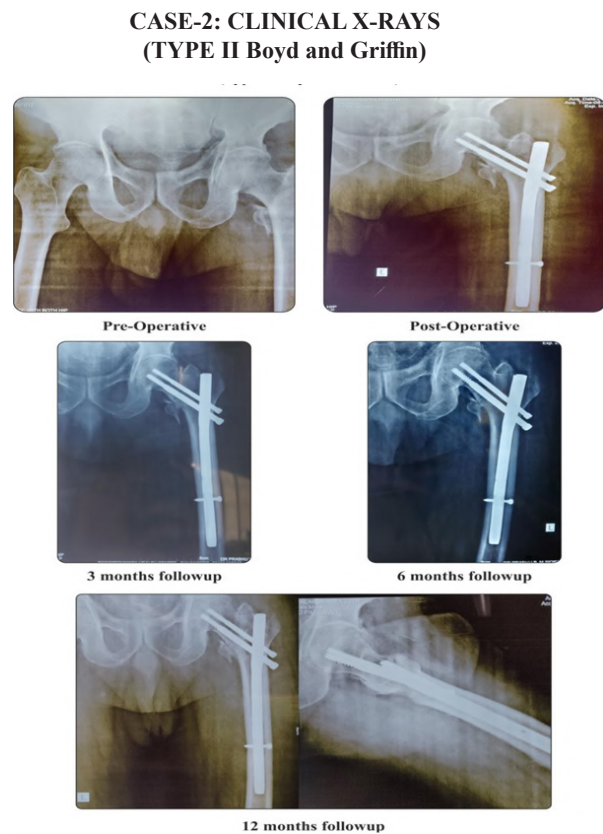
Plain radiograph of left hip anteroposterior and lateral view showing Pre-operative, post-operative and follow up images at 3,6 and 12 months respectively.
